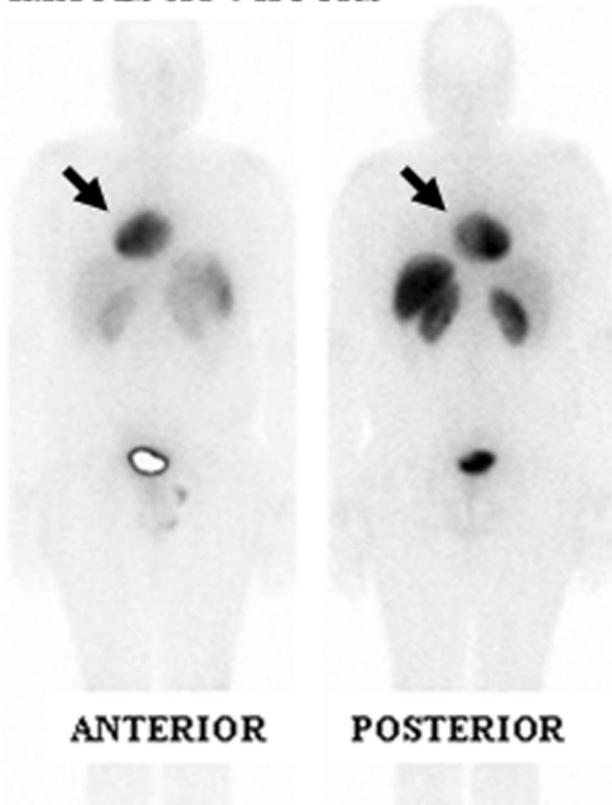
¹¹¹In-octreotide scintigraphy (OctreoScan) whole body images obtained 4 hours after injection showing abnormal high uptake by the mass (black arrow) and normal uptake by the liver, kidneys, and bladder.
